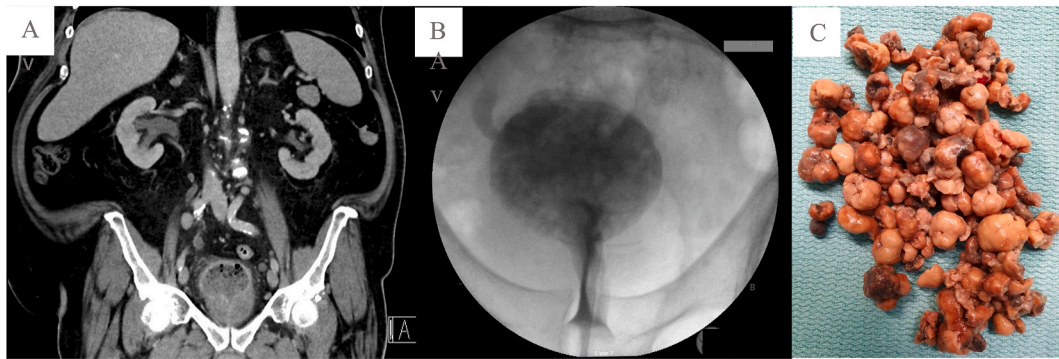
(A) CT scan of the abdomen: thickened urinary bladder, partly filled with air, (B) cystoscopy: reflux and material within the bladder, gas bubbles, (C) spongy material.
